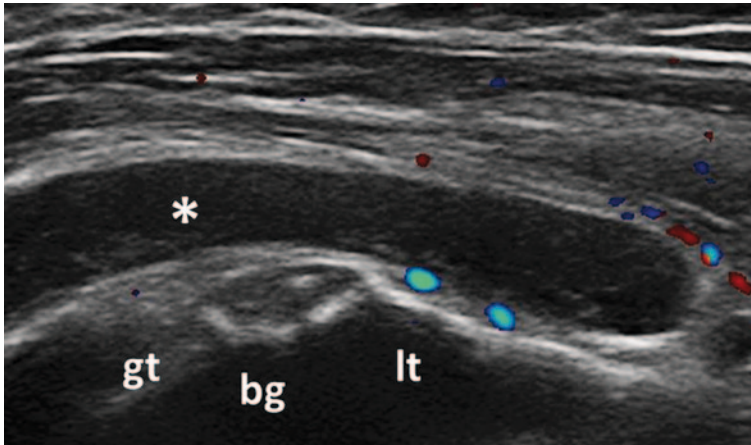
Transversal view over the bicipital groove showing subacromial subdeltoid bursitis (*asterix*); Doppler signal is seen outside the bursa; *gt* greater tuberosity, *lt* lesser tuberosity, *bg* bicipital groove
